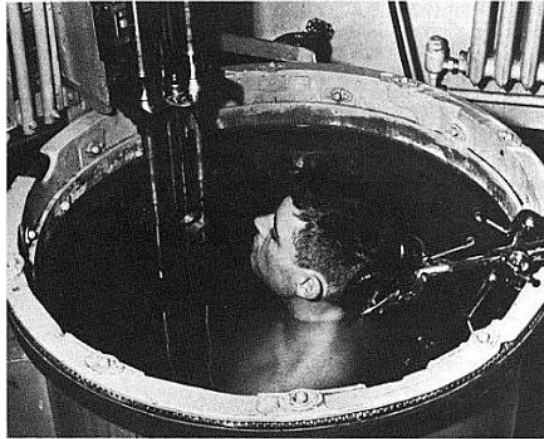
One of the first diagnostic ultrasound devices - The gun turret from a B-29 bomber was converted to obtain a ultrasonic tomographic system. After Szabo [113].
